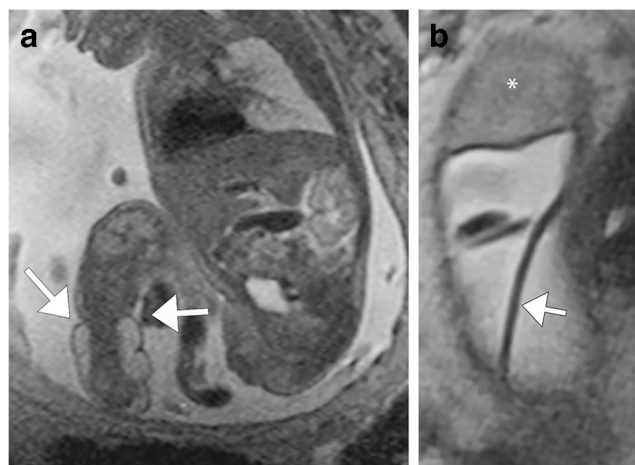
Amniotic bands. a Sagittal single-shot turbo spin-echo (SSTSE) MR image in a 25-week fetus shows an amniotic band constricting the mid-lower extremity, with marked soft-tissue swelling distal to the constricting band (arrows) and resulting vascular compromise. The band was fetoscopically lysed, resulting in return of vascular flow to the lower extremity. b Coronal MR image with respect to the maternal uterus in this 21-week gestation fetus shows incidental synechia (arrow) crossing the gravid uterus. A synechia should not constrict fetal parts
